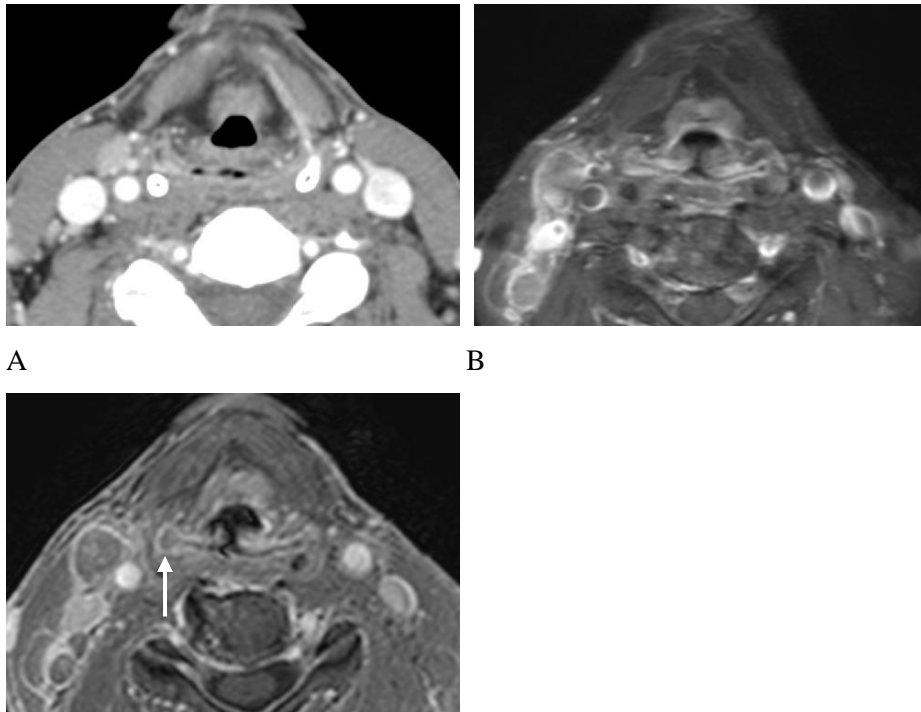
Delineation of the primary tumor in a 44-year-old woman with left tonsil cancer and metastatic cervical lymph nodes. Contrast-enhanced CT (A) and T1-weighted gadolinium-enhanced MR images (B) show mild asymmetric enlargement of the left tonsillar fossa. Postcontrast T1-weighted high resolution isotropic volume examination MR image (C) reveals more apparent delineation of the primary tumor with obliteration of the tonsillar crypts in the left palatine tonsil (arrow).
